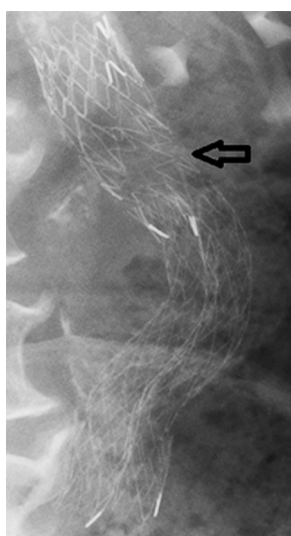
Plain abdominal X-ray of a patient treated with a Vanguard® stent-graft who suffered a row separation of the stent-graft during follow-up.
